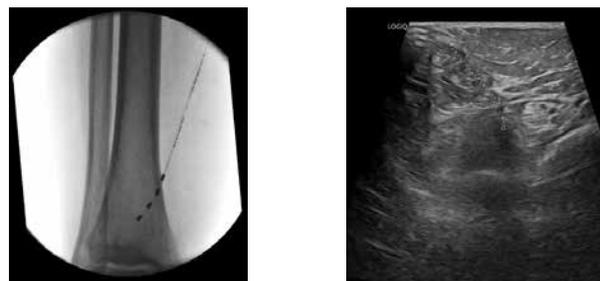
Fluoroscopic and ultrasound images showcasing the placement of PNS trial leads. PNS, peripheral nerve stimulation.
